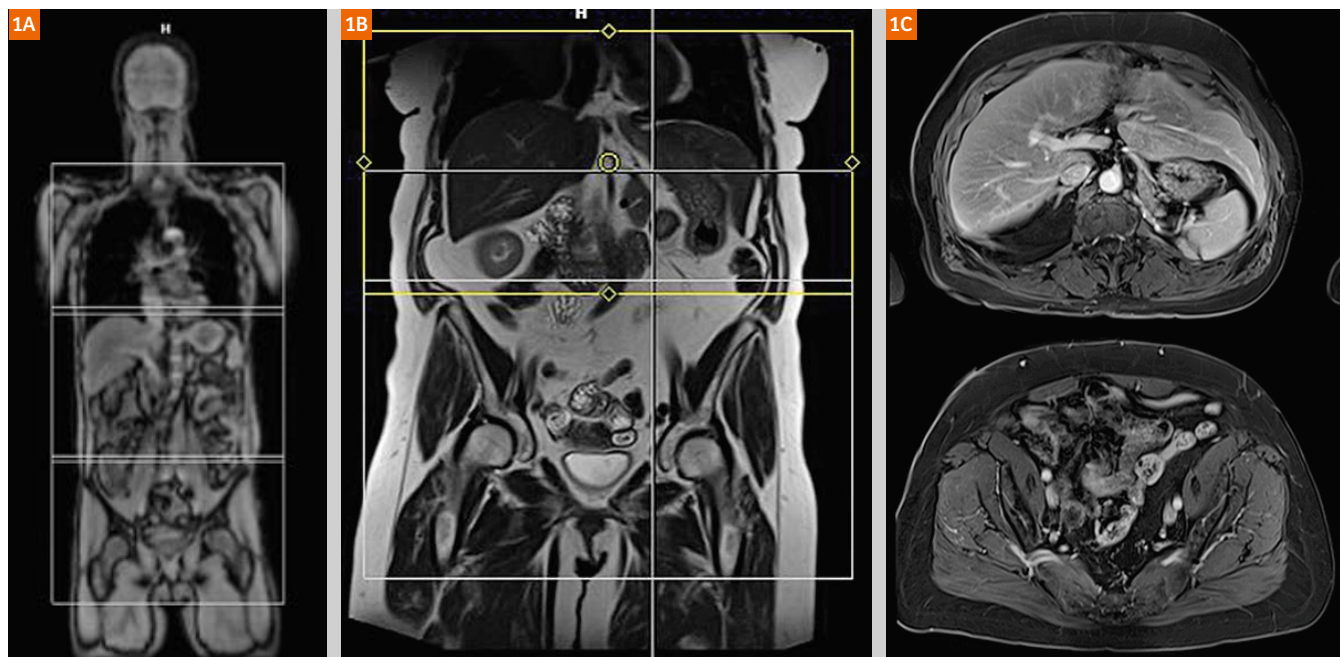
(1A) Fast low resolution whole-body scout with automatically segmented abdomen and pelvis for multi-station scanning. (1B) Coronal T2 single-shot turbo-spin-echo images with automatically segmented abdomen and pelvis split into two blocks for the transverse T1-weighted sequence (1C) with an acquisition time of 15 s for each lying within the preset 20-second breath-hold capacity. The cranio-caudal coverage per block is set to 400 mm with a fixed overlap of 2 cm between blocks and is adjusted to patient size and breath-hold capacity.
